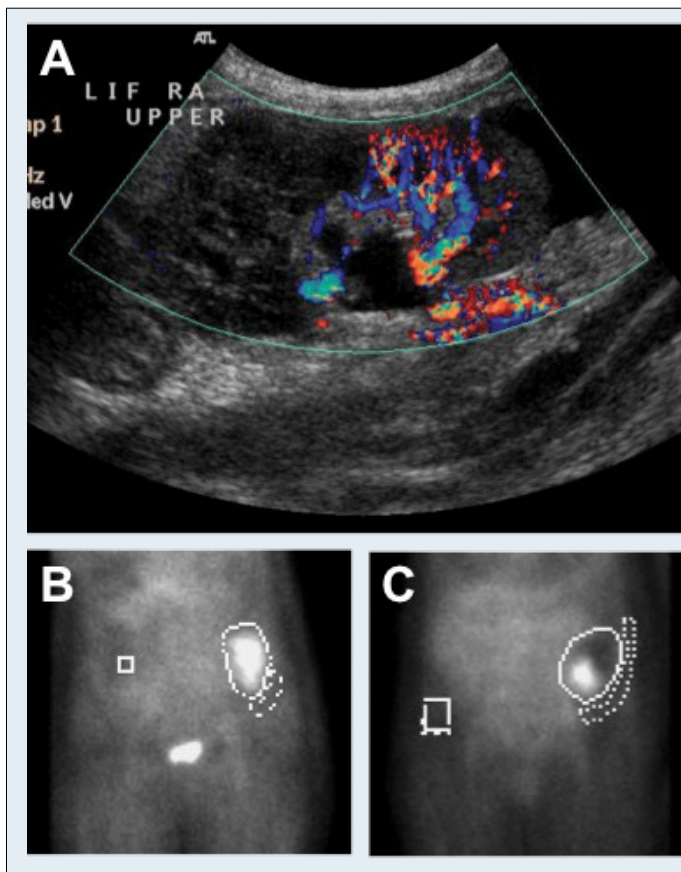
(A) Day 5 renal transplant ultrasound showing absent flow at the upper pole of the transplanted kidney. (B) Day 1 renal MAG3 scan (performed prior to the thrombosis of the arterial branch) with uptake of tracer throughout all poles of the transplanted kidney. (C) Day 5 Renal MAG3 scan showing absent uptake of tracer at the upper pole of the transplanted kidney.
